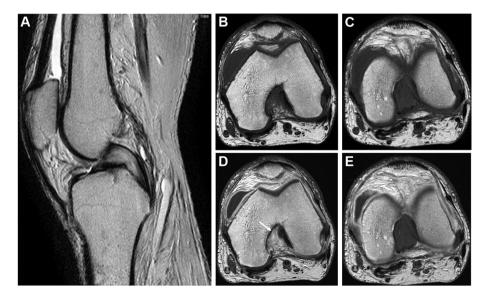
Preoperative magnetic resonance imaging. Preoperative T2-weighted sagittal image showed tram-track appearance (A). Preoperative T1-weighted axial image (B, C). Preoperative T1-enhanced axial image showed contrast effect (arrow) at the posterior cruciate ligament (PCL) proximal intercondylar femoral attachment side (D), but not at the PCL tibial attachment side (E).
